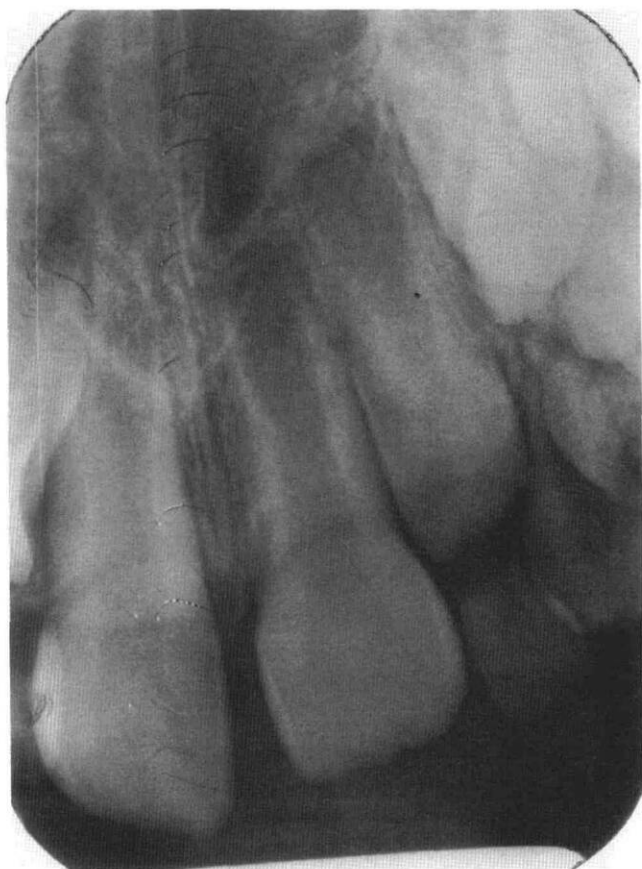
Periapical radiograph of the maxillary central incisors. Formation of the crown and root of the left incisor appears to be normal, although eruption is slightly delayed. Note that the tooth and bone appear uninvolved and no unusual radiopacities are present.
